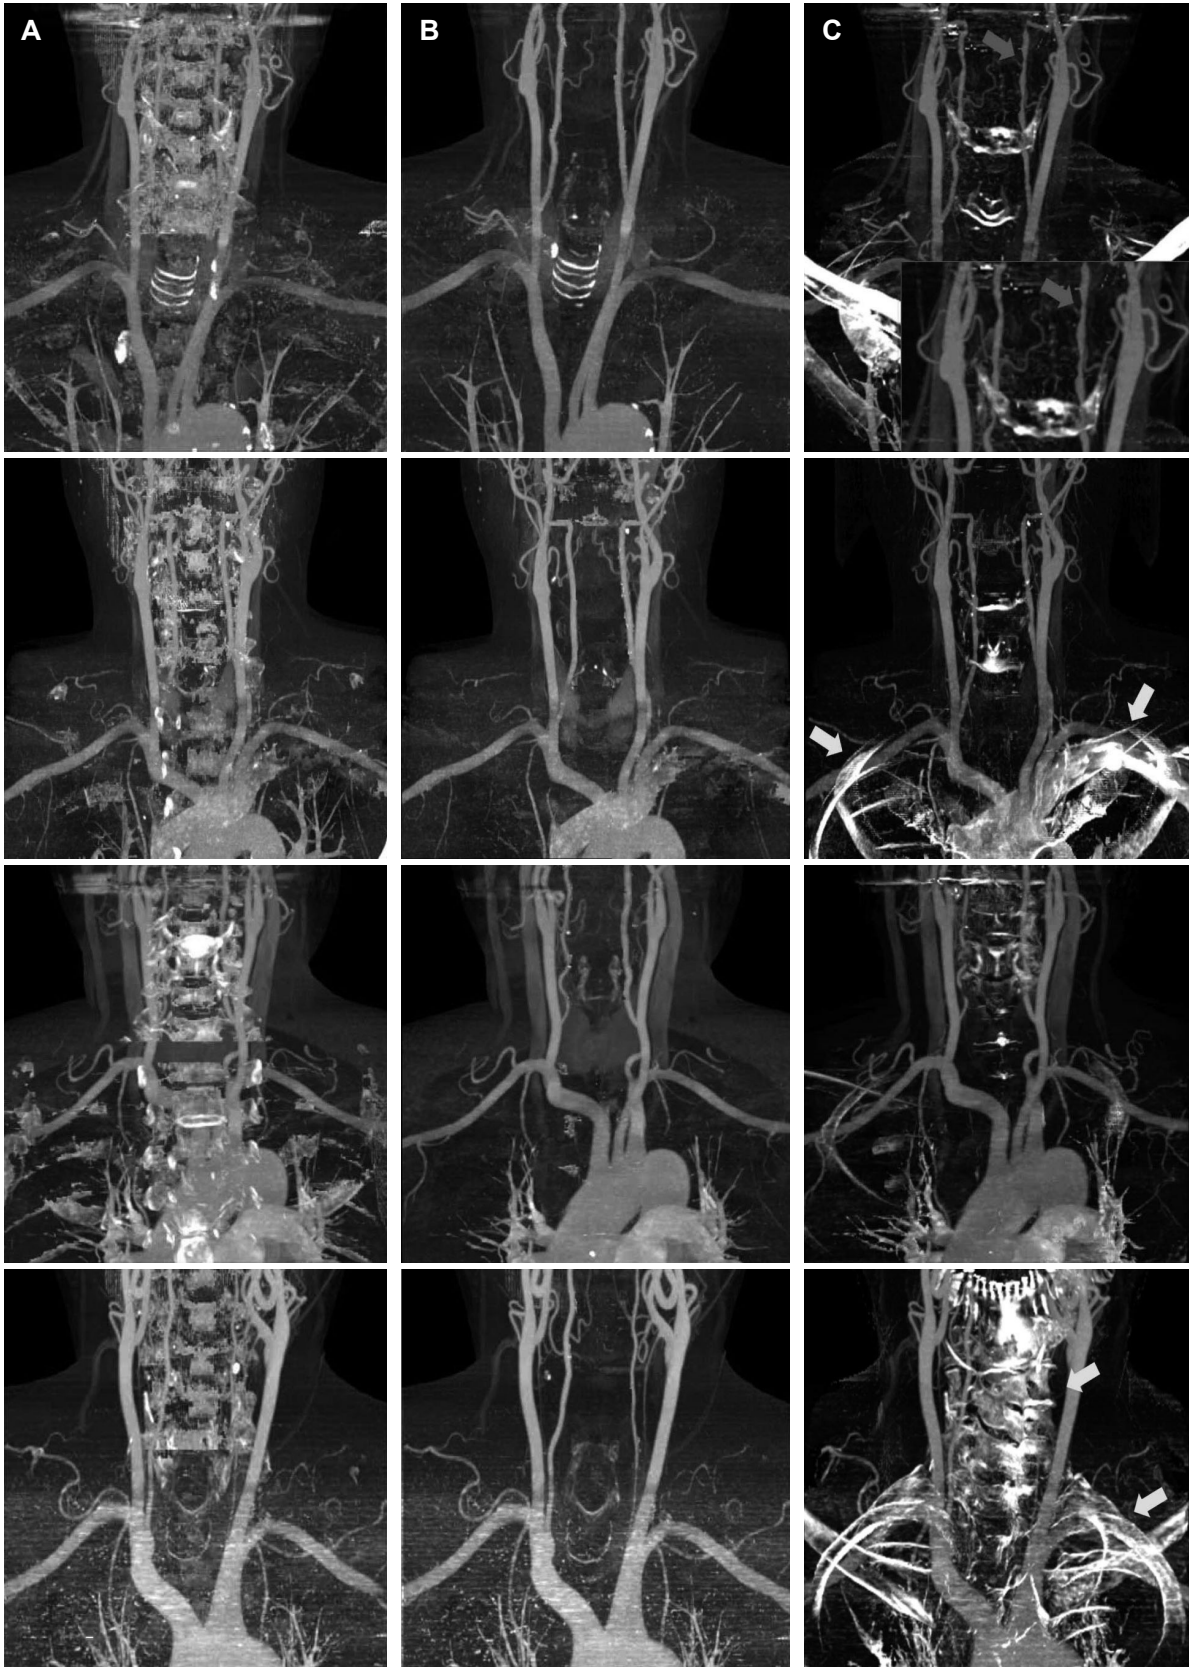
The results of automated segmentation of vertebral arteries in head and neck CT angiography. (A) Density-based segmentation (B) the proposed method and (C) registered subtraction are displayed as Maximum Intensity Projection.
